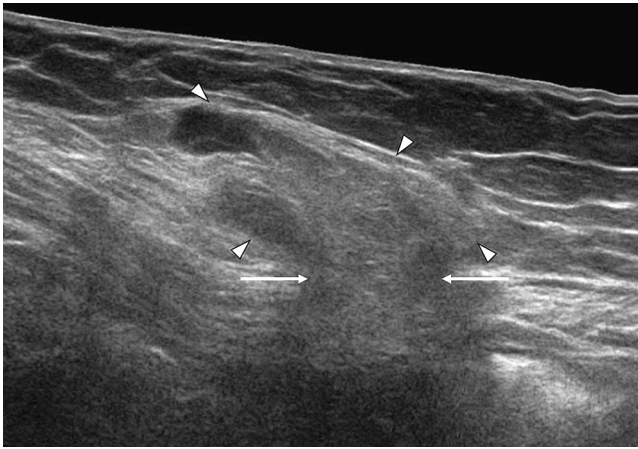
Spigelian hernia. Transverse sonogram right loin region. Hernia sac (arrowheads) that contains both fluid and mesentery, extending through a defect in the abdominal wall (arrows) just lateral to the rectus abdominis muscle (not shown).
